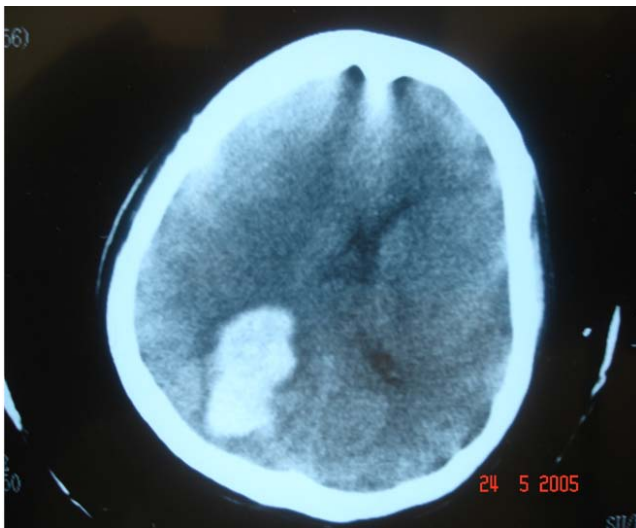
Patient CT-Scan.
